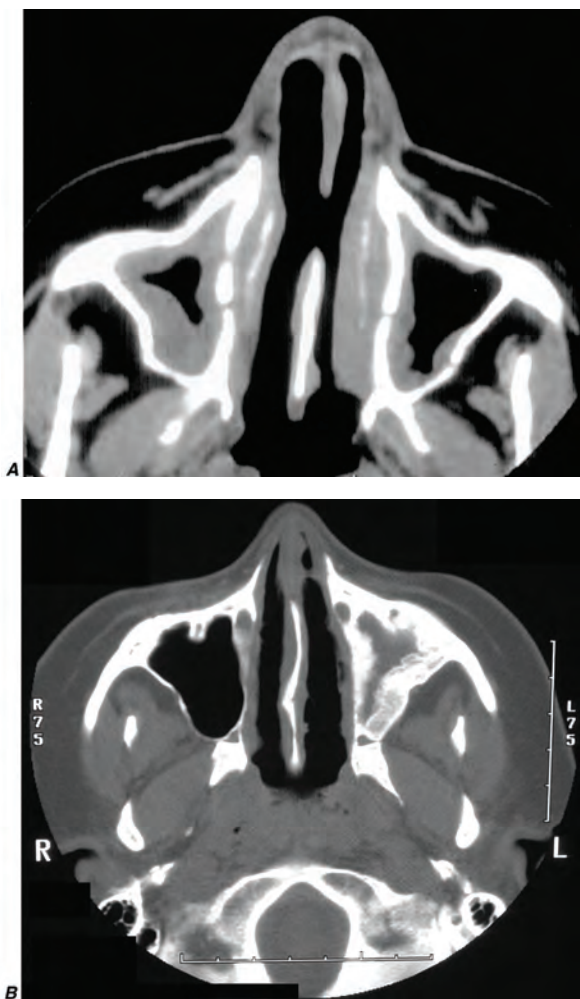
Figure e40-6 Computed tomography of the sinuses in two patients with granulomatosis with polyangiitis (Wegener's) (*A*) Mucosal thickening of the bilateral maxillary sinuses and a perforation of the nasal septum. (*B*) Osteitis with obliteration of the left maxillary sinus in a patient with long-standing sinus disease.
